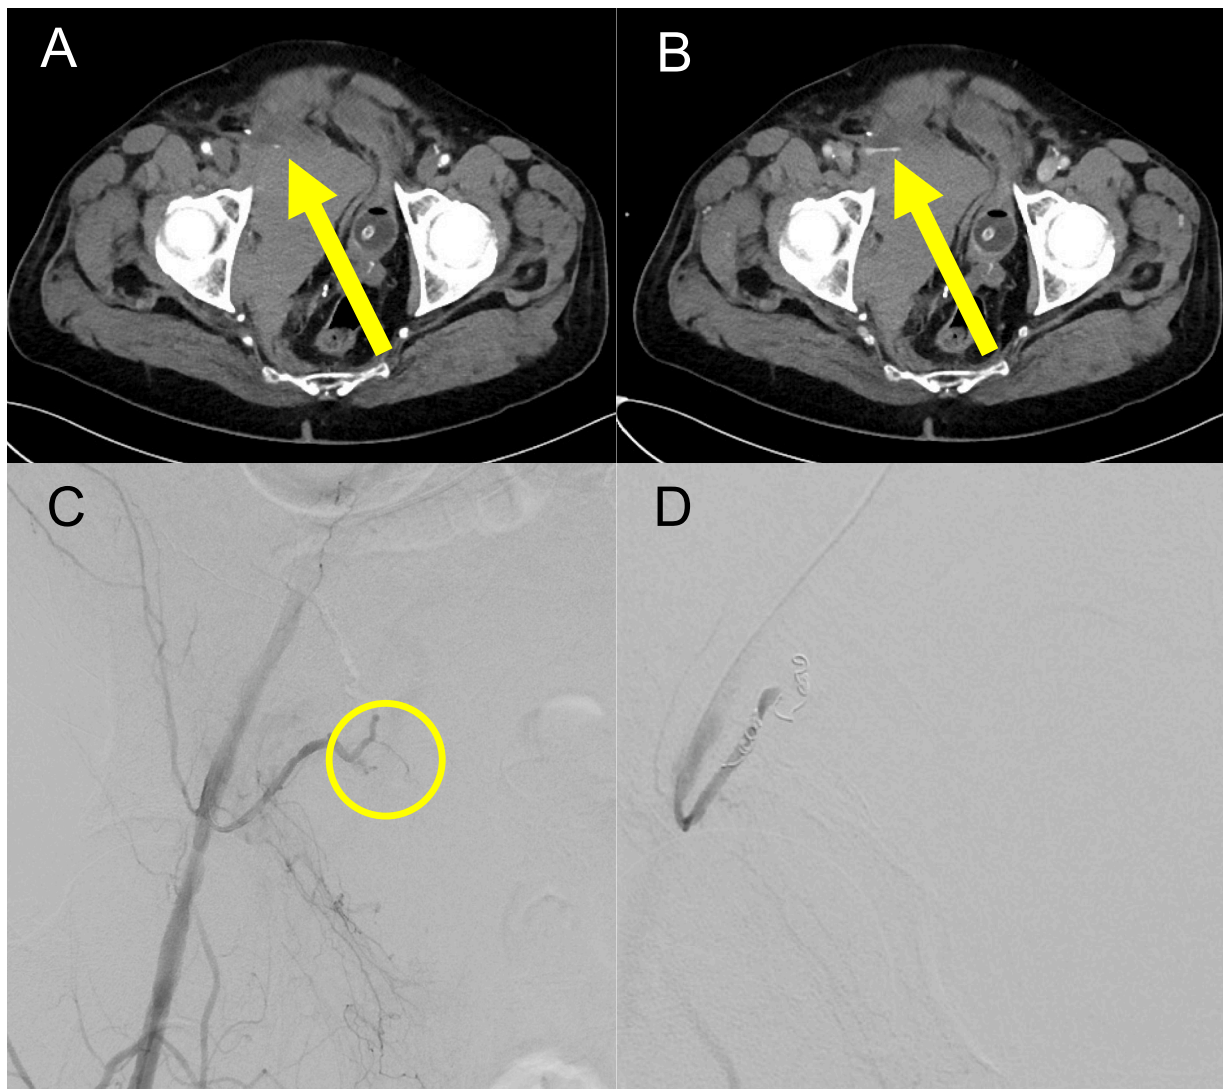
A 60-year-old male patient with COVID-19 infection without ECMO or anticoagulation treatment developed an active arterial bleeding from the inferior gastric artery with a large hematoma in the CT in the arterial (A) and porto-venous phase (B). (C) In the angiography, extravasation of contrast media from the inferior gastric artery could be seen and endovascular treatment was performed. The inferior gastric was occluded with coils gelatine sponge to stop the bleeding. (D) In the control series, no extravasation of contrast media could be detected.
